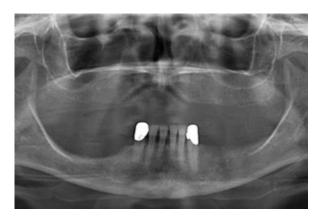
Initial panoramic X-Ray
